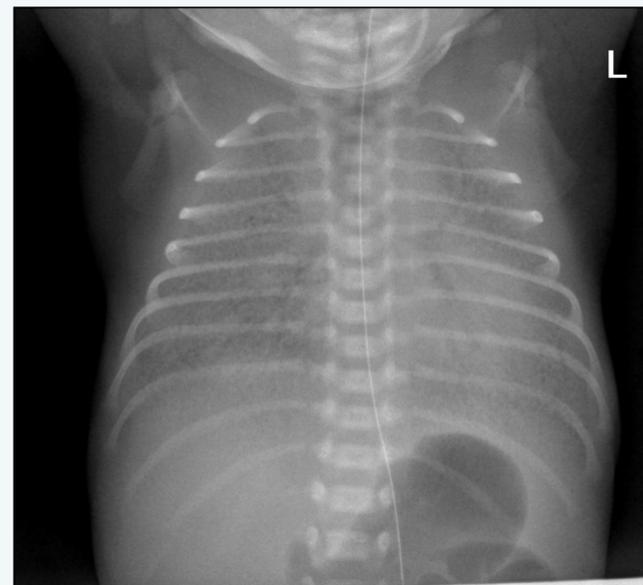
Sample chest x-ray of RDS. Note underinflated lung fields, bilateral granular opacities, & air bronchograms.
